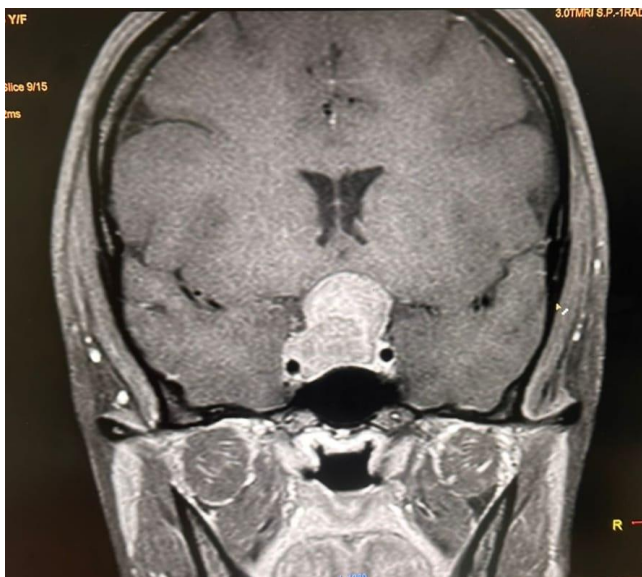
CE-MRI Brain with pituitary protocol revealed a diffusely bulky, dumbbell-shaped pituitary gland measuring 11.8 mm in height, showing homogeneous post-contrast enhancement, abutting the cavernous portion of the internal carotid arteries bilaterally, with optic chiasma spared.
